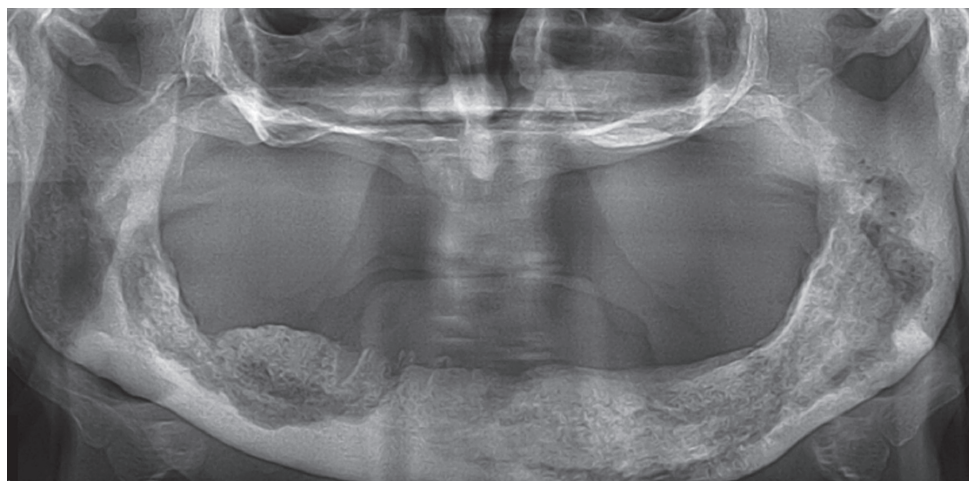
Orthopantomograph of a patient with significant pathologic bone changes in BRONJ.
